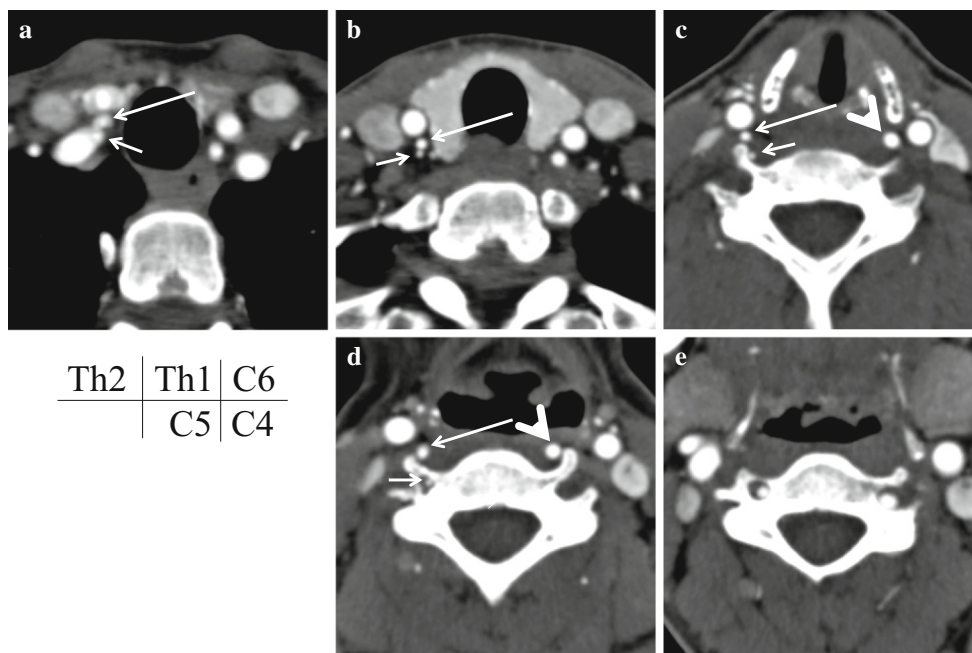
Computed tomography angiography source images of the neck region. a At the level of the Th2 vertebral body, two channels of the right vertebral artery (VA) arise from the extreme proximal right subclavian artery (long and short arrows). b At the level of the Th1 vertebral body, two channels of the right VA ascend near to each other (long and short arrows). c At the level of the C6 vertebral body, bilateral VAs are not
